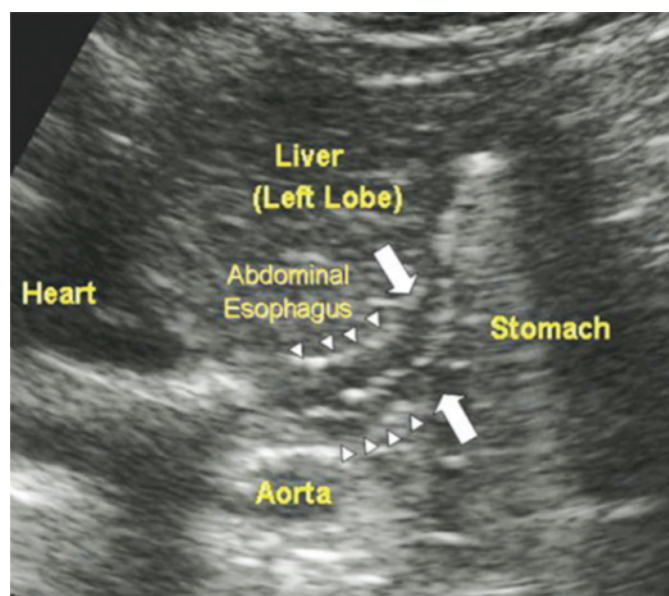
Transverse oblique ultrasound of the gastroesophageal junction (arrows). The esophagus seen as a tubular structure (arrowheads) with a hypoechoic wall (muscular layer) and a hyperechoic center (mucosa and lumen)⁸.
